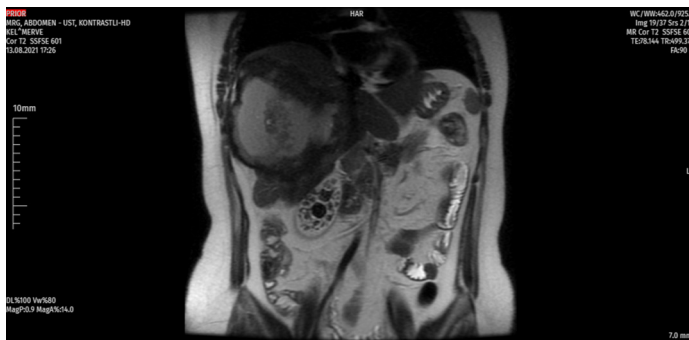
Upper abdomen MRI coronal section view of multiple gallbladder stones
